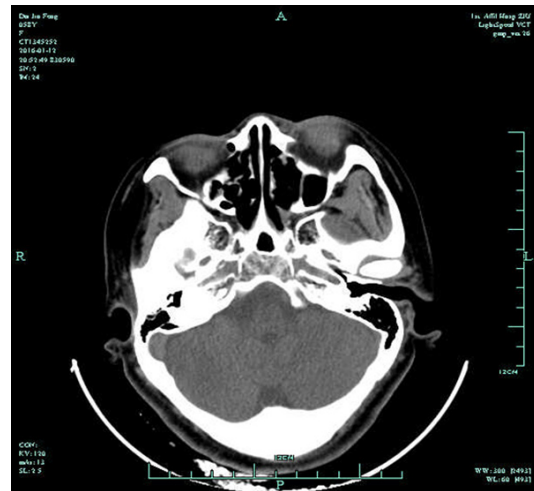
Axial CT scan of the paranasal sinuses showed that the patient was followed up for 18 months without recurrence.
